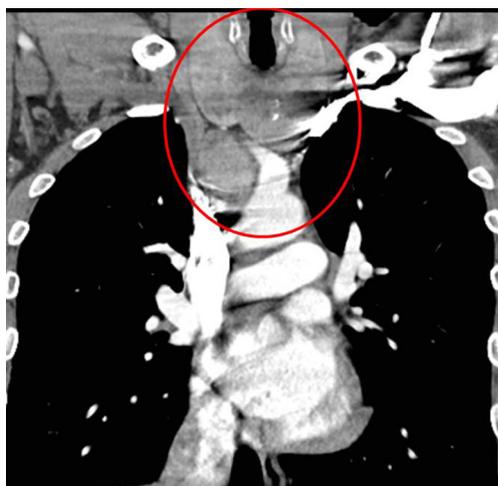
Cervico-thoracic CT scanner showing substernal goiter, frontal view.
